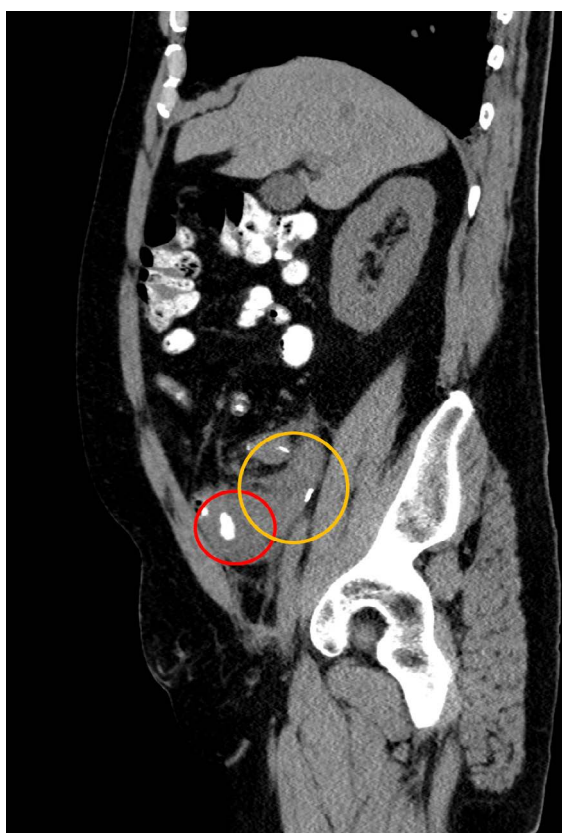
Inflamed Jejunum Marked by red circle on coronal CT images
